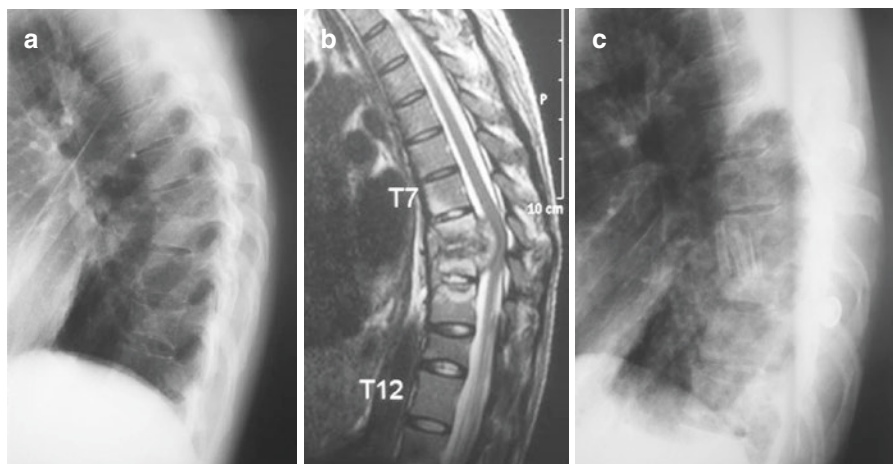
(a–c) This T8–T9 TB spine patient received anterior debridement and fusion using autogenous rib grafts through left thoracotomy. (a) Lateral thoracic spine radiograph. (b) T2-weighted sagittal MRI. (c) Postoperative lateral thoracic radiograph
